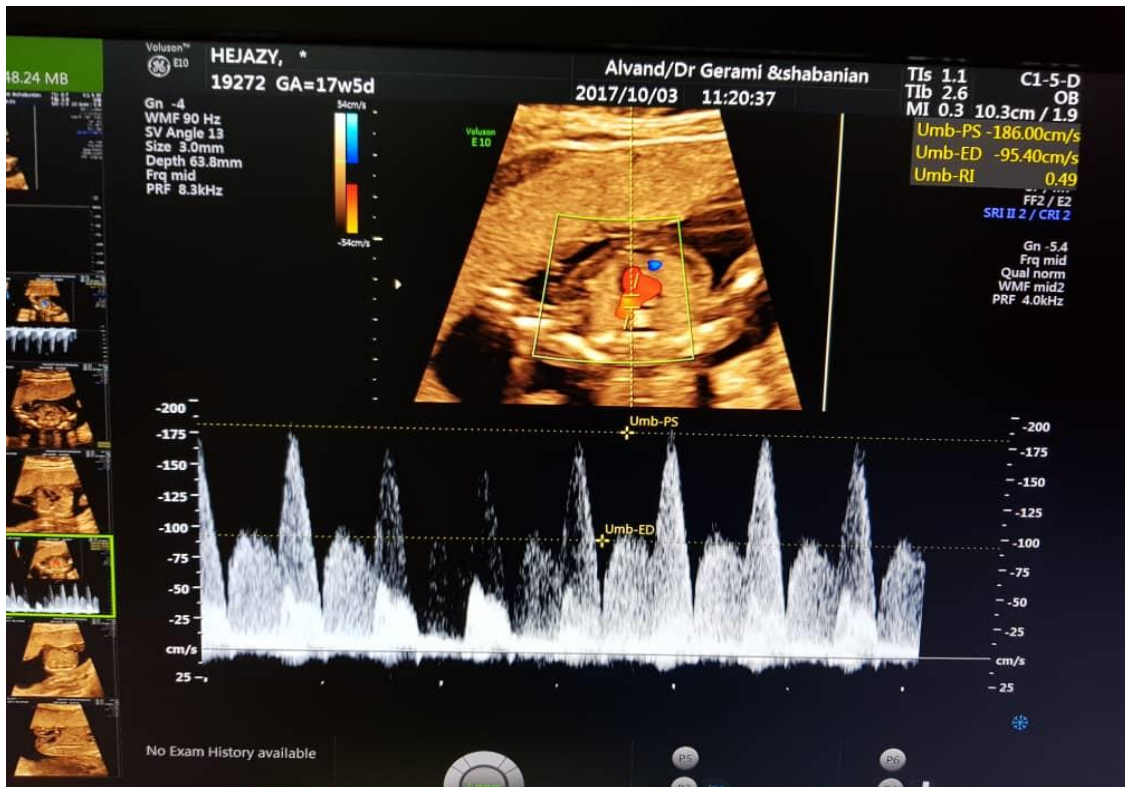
Doppler waveforms of the DA showing typical high velocities in systole (186 cm/s) and a second peak in diastole (95 cm/s) with a high pulsatility index (0.9).
